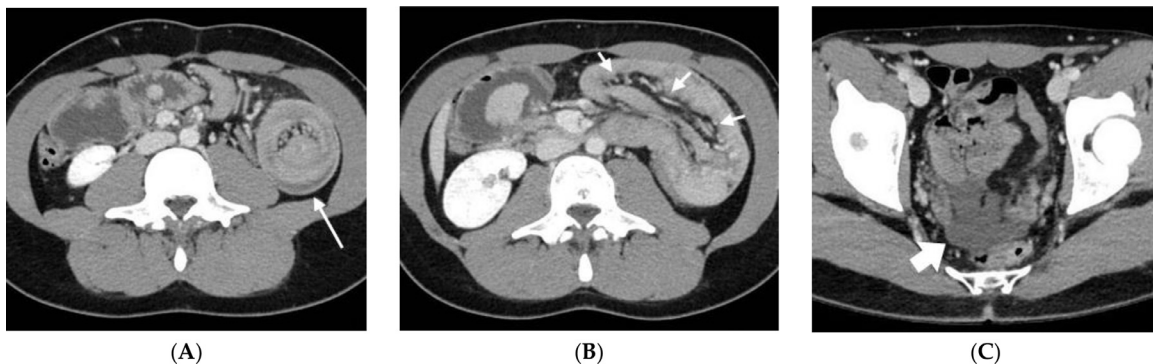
(A) The "target sign" on axial CT image with a typical "double-wall" appearance (long arrow); (B) The characteristic central low-attenuation fat and mesenteric vessels of intussusception (short arrows); (C) Free fluid in the pelvic cavity (fat arrow).
